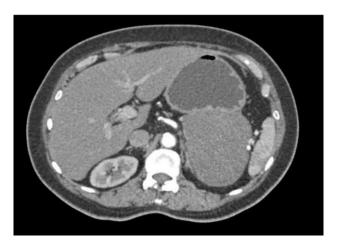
Axial section CT abdomen showing GIST in the stomach.
